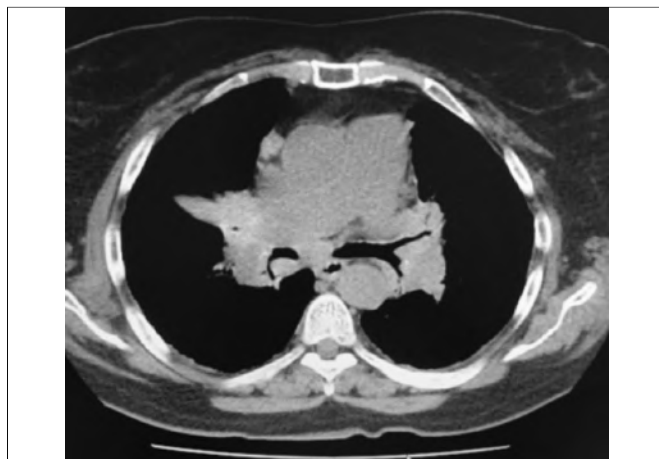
Thorax CT revealed endobronchial lesion in the middle lobe bronchus.
